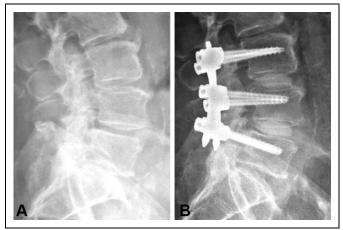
Representative case of L3-L5 awake endoscopic minimally invasive transforaminal lumbar interbody fusion. (A) Preoperative lateral lumbar radiograph demonstrating intervertebral settling with top-down foraminal stenosis at L3-4 and L4-5. (B) Postoperative lateral lumbar radiograph after endoscopic decompression and interbody implant placement, with restoration of intervertebral height and foraminal decompression.
